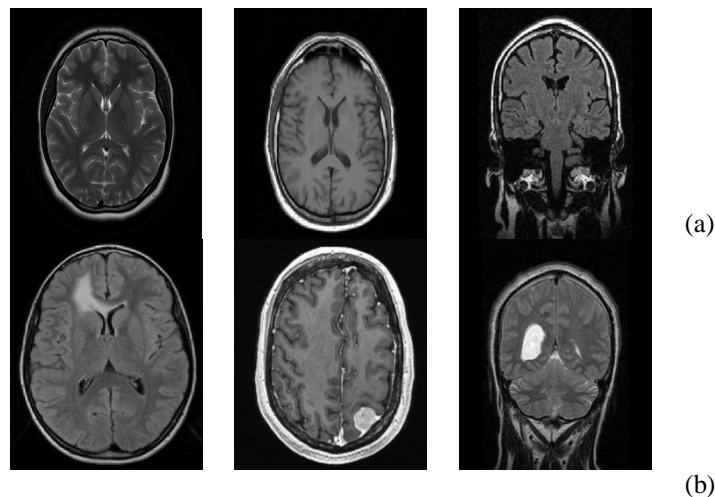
MRI brain images (a) Typical MRI brain images (b) MRI brain images with the tumor.
